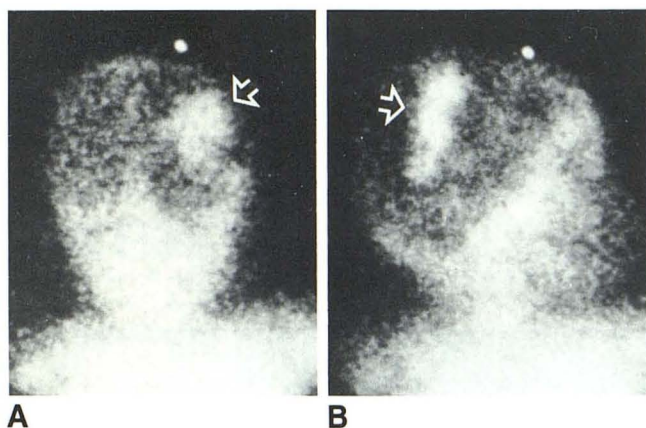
Posterior (A) and right lateral (B) cranial scintigrams obtained 1 hr after injection of ^{99m}Tc sulfur colloid. Right parietal accumulation of radionuclide (arrows) indicates active intracranial bleeding. Bone marrow activity in skeleton and pulmonary activity are physiologic findings.
